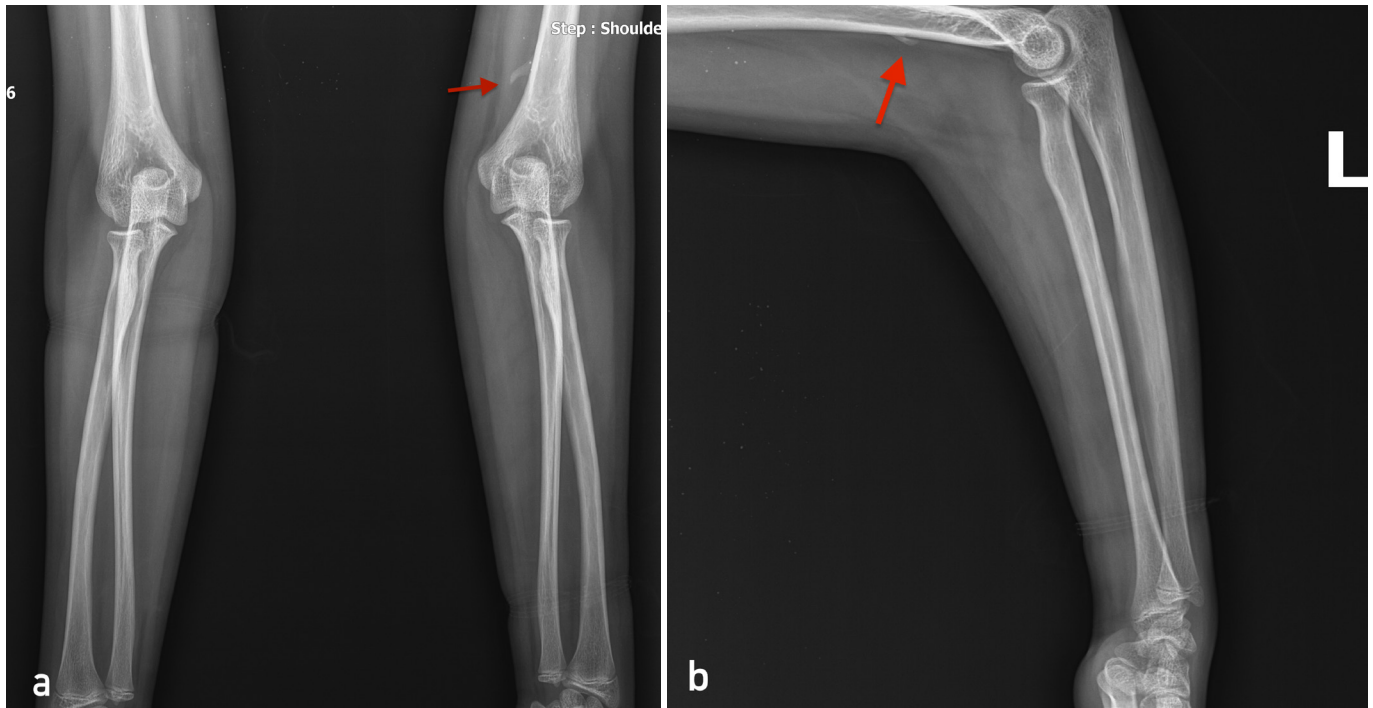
A beak-shaped radiodense structure (red arrow) with a smooth surface observed on anteroposterior (a) and lateral radiographs (b). This structure is sharply circumscribed and demonstrates continuity from the cortex on the left, superior to the medial epicondyle (red arrow).
